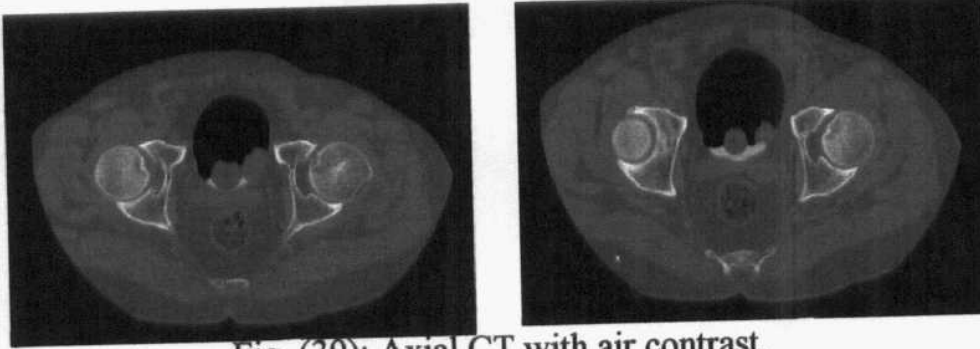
Axial CT with air contrast.
